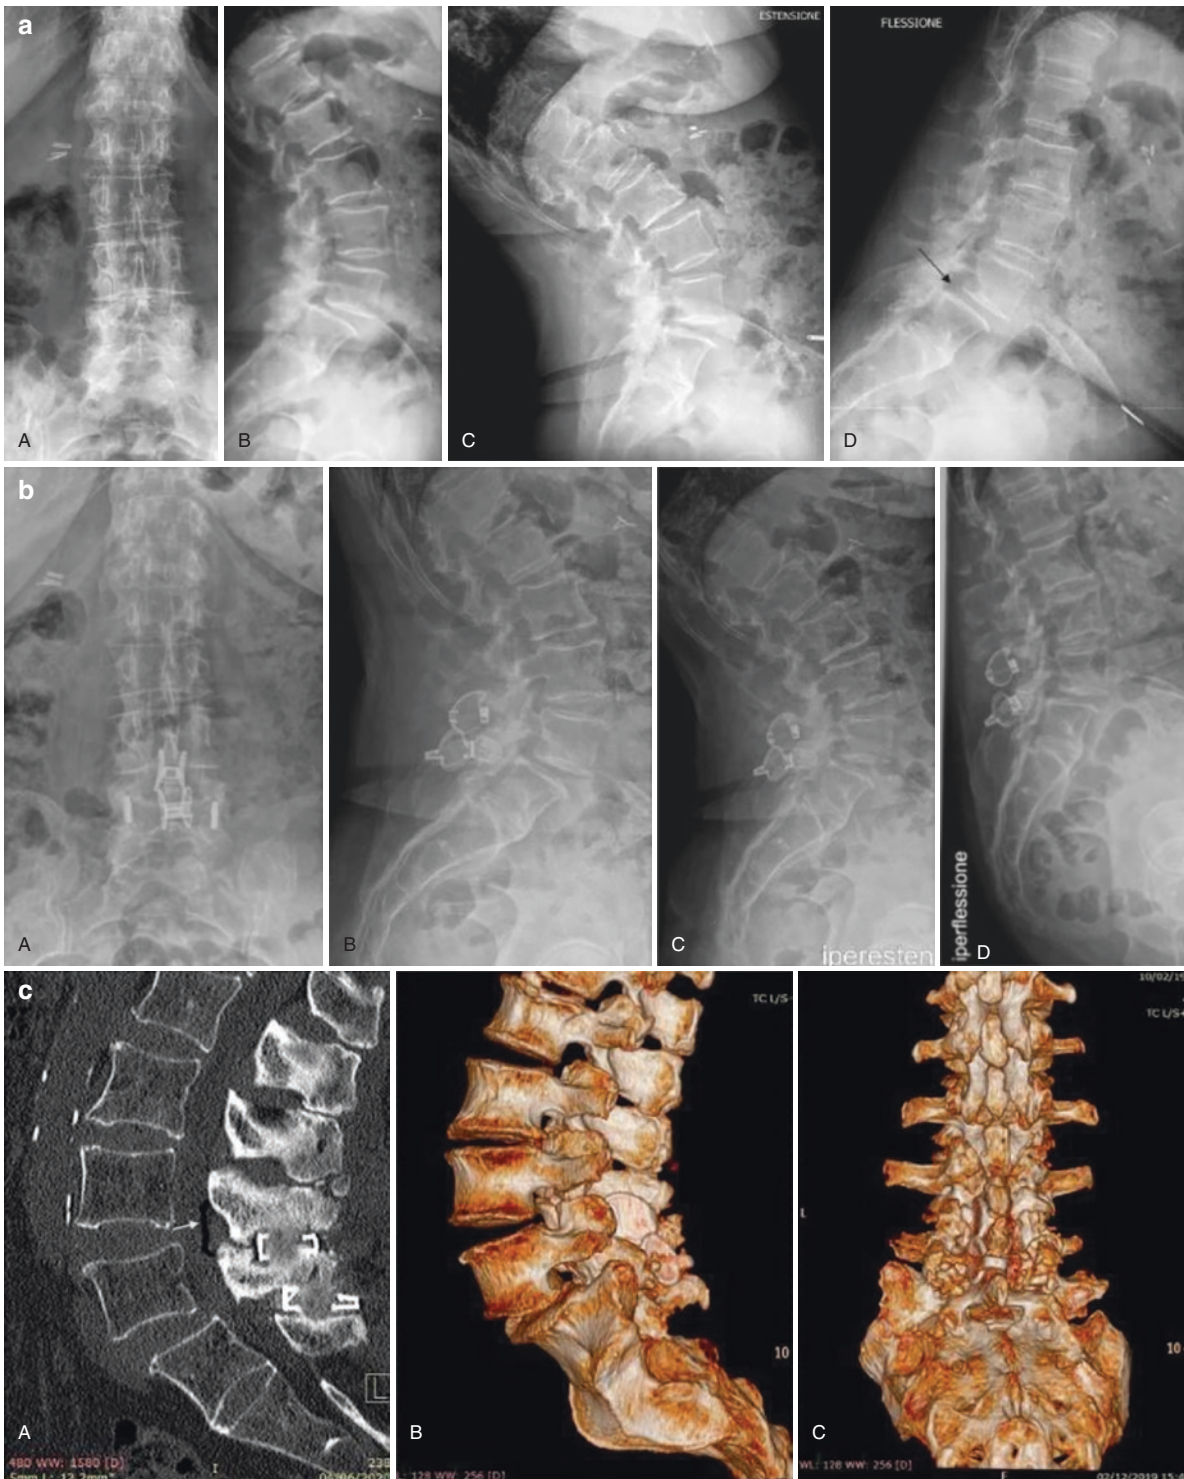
(a) Preoperative dynamic X-ray with mild instability in the L4-L5 level (S1 lumbarization); (b) the same dynamic postoperative X-ray with good stability in the L4-L5 level after the decompression;
